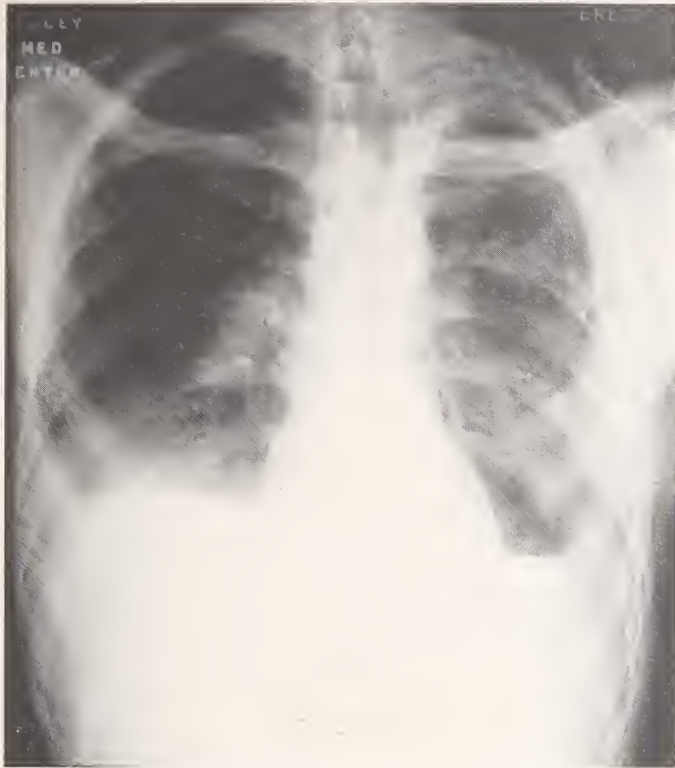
Chest roentgenogram after decortication.
